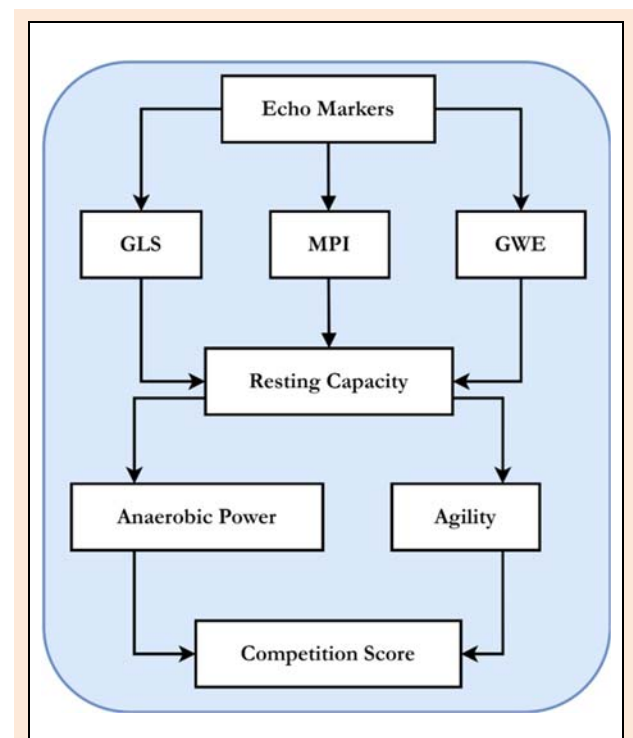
Three-layered martial arts performance framework linking echocardiographic markers, capacity, and outcomes.
